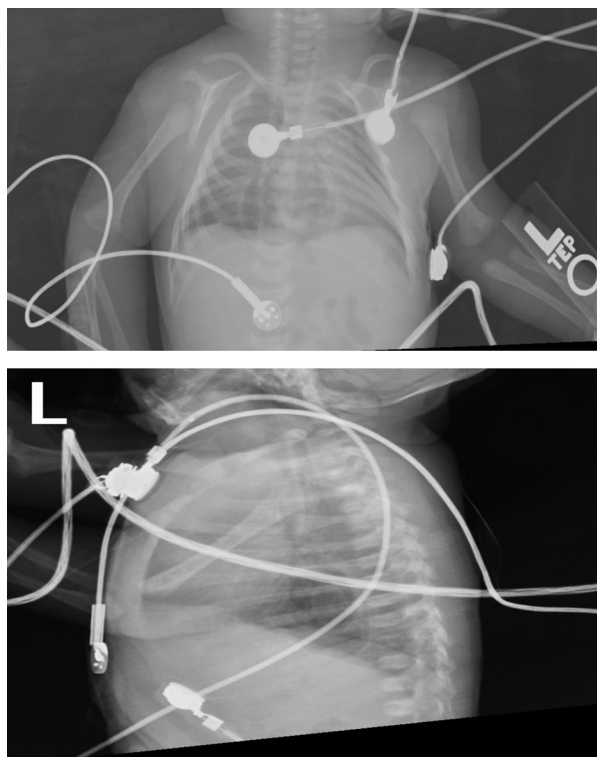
Day of life 0. Frontal and lateral radiographs demonstrate lucency over the lower chest suggestive of a hernia.
